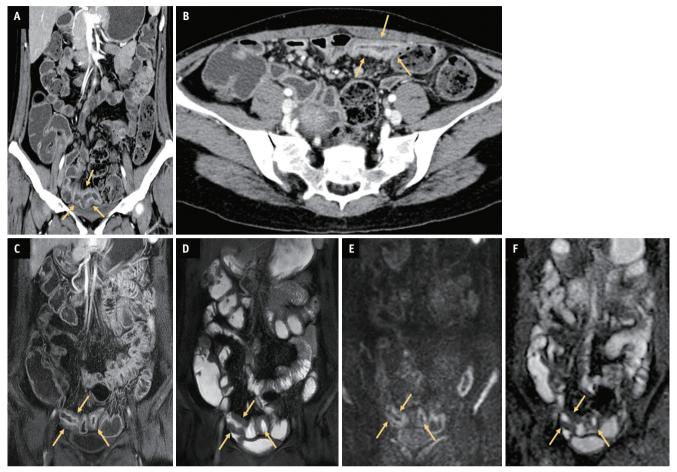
A 52-year-old (at initial diagnosis) female with chronic enteropathy associated with *SLCO2A1* gene (CEAS) who was initially evaluated with computed tomography enterography (CTE) and then followed with magnetic resonance enterography (MRE). CTE images (A, enteric phase; B, portal phase) show an ileal segment involved with CEAS (arrows) which demonstrates circumferential wall thickening with stratified enhancement in the distal ileum. On a follow-up MRE (C, enteric-phase contrast-enhanced T1; D, fat-saturated T2; E, diffusion-weighted imaging; F, apparent diffusion coefficient map) at 130 months from the CTE, the lesion (arrows) shows similar findings, except for a slight increase in mural thickness. The involved bowel wall shows a slightly increased signal on T2 and mild restricted diffusion.
